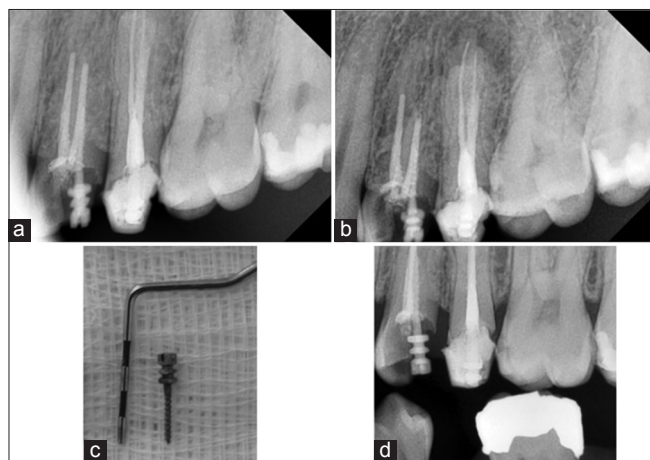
Maxillary left first premolar. (a) Straight periapical radiograph. (b) Mesial periapical radiograph. (c) Pre-operative photograph of the upper jaw. (d) bitewing radiograph of the right premolar teeth
